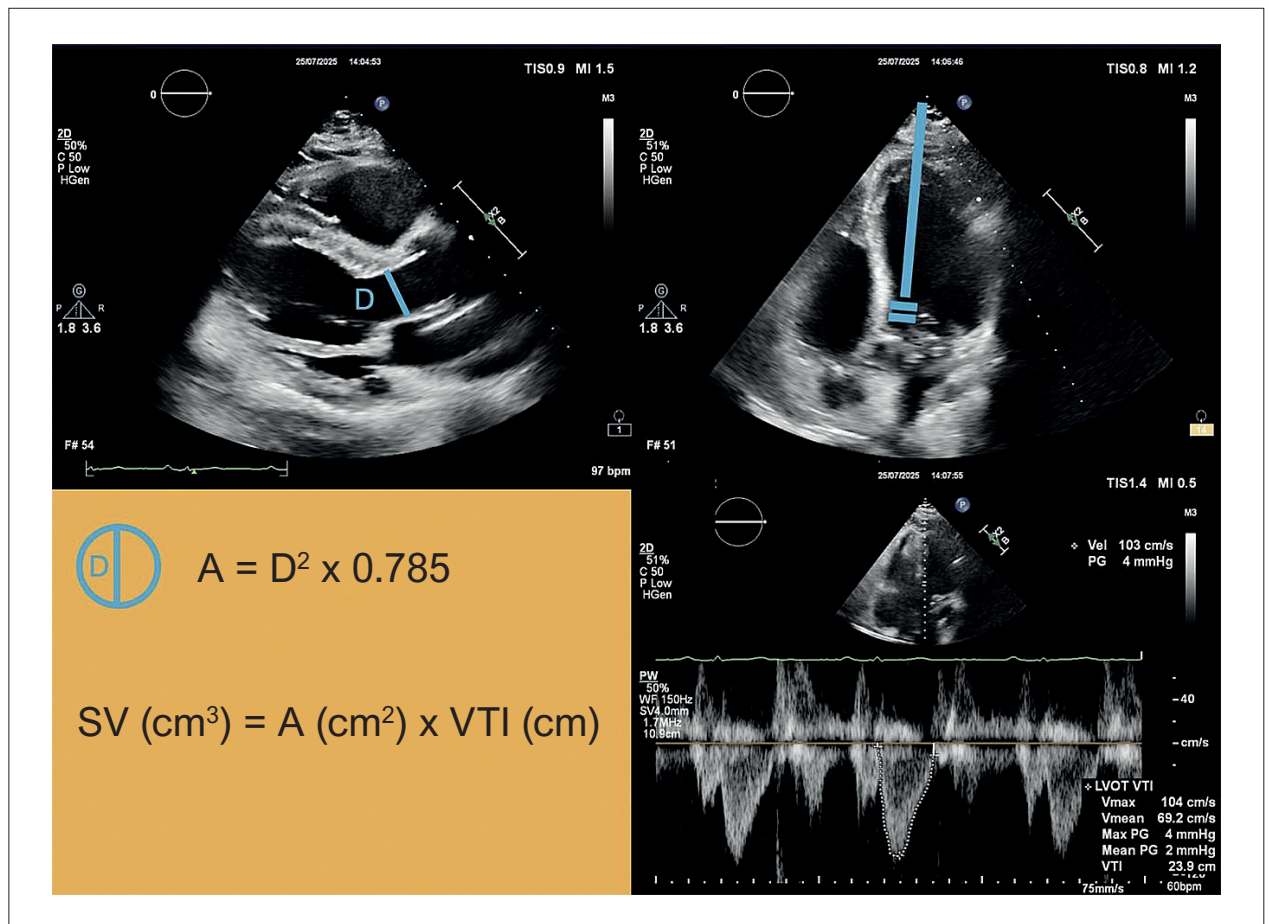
Calculation of stroke volume by multiplying the area of the left ventricular outflow tract obtained from the parasternal window by the left ventricular outflow tract flow integral obtained from the apical five-chamber view.⁵¹ A: area; D: diameter; SV: stroke volume; VTI: velocity time integral.
